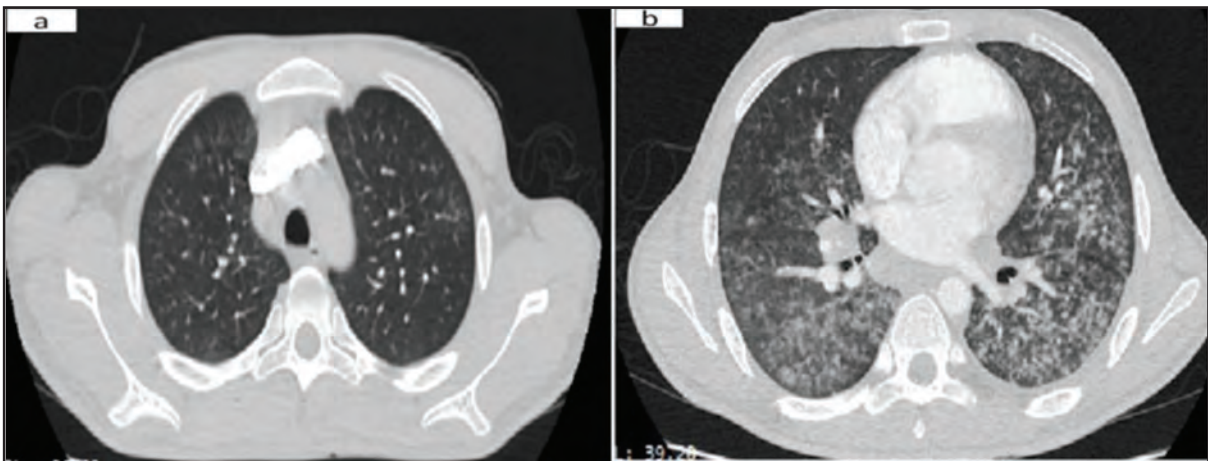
Contrast-enhanced CT thorax showing centrilobular nodules with TIB opacities, especially at lower lobes. a) A slice of upper lobes. b) A slice of lower lobes.
